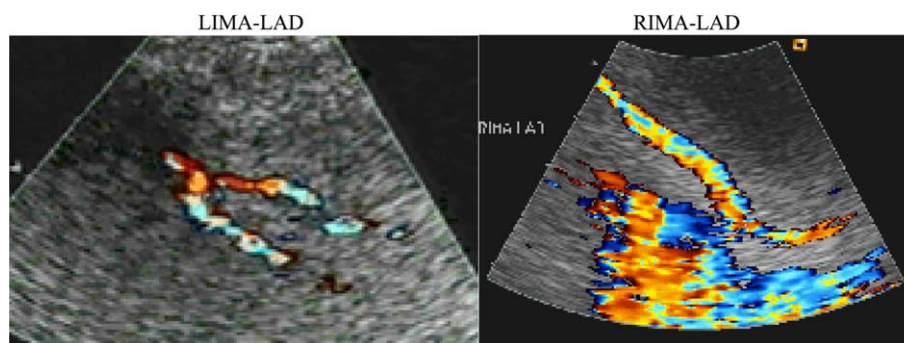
Transthoracic colour-Doppler imaging of the left internal mammary artery (LIMA) and the right internal mammary artery (RIMA) grafted over the left anterior descending coronary artery (LAD).
